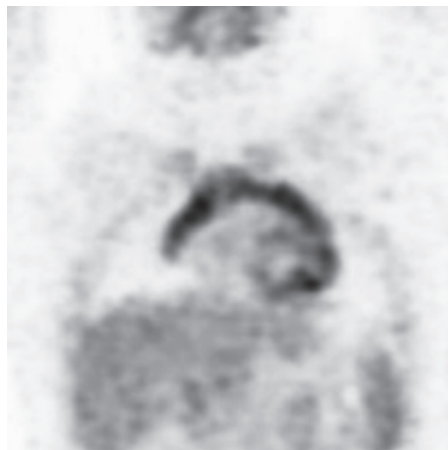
Coronal FDG PET scan shows diffuse and homogeneous uptake in the normal thymus. The uptake is bilobed with an inverted V shape.
